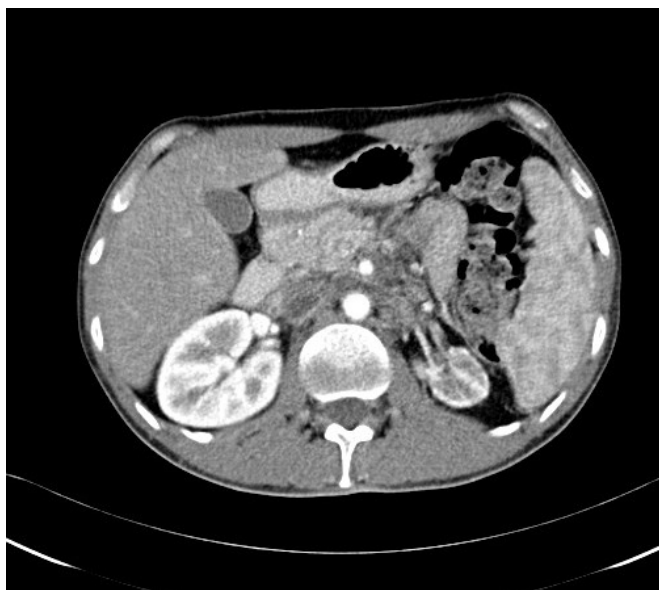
(a) Axial CT image and (b) coronal reformatted image, showing large IVC thrombus extending into bilateral renal veins
